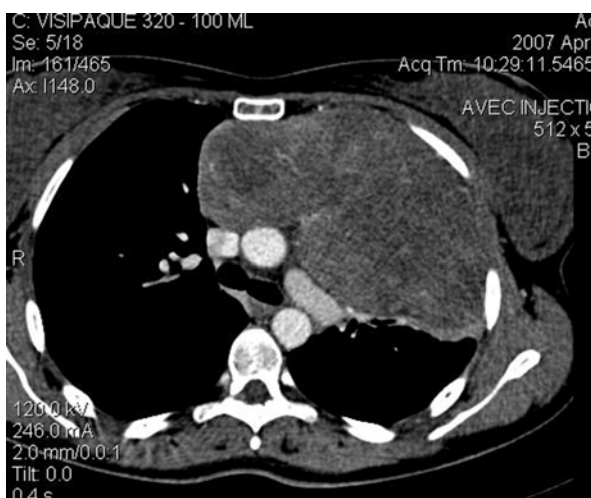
Chest computed tomography scan revealing an anterior necrotic and solid mass of the mediastinum compatible with a teratoma.
